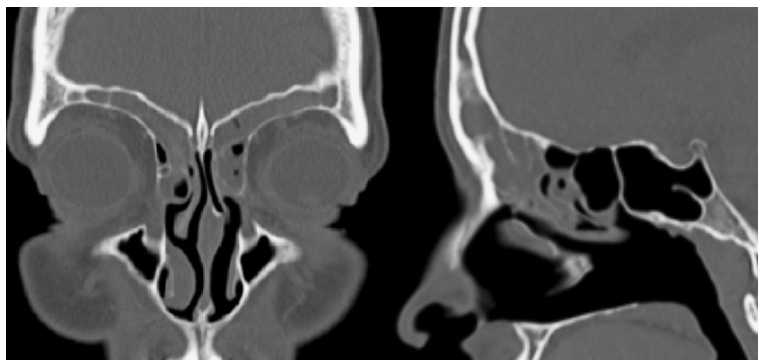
A representative CT scan of one CRSsNP patient in frontal view (left) and sagittal view (right), CT Lund MacKay score 8.
